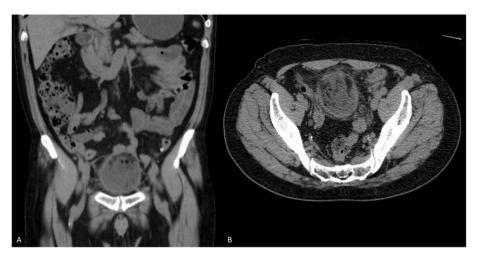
Abdominal computed tomography showing a bladder mass involving the bladder dome, with heterogeneous content. A. Coronal section B. Axial section.
